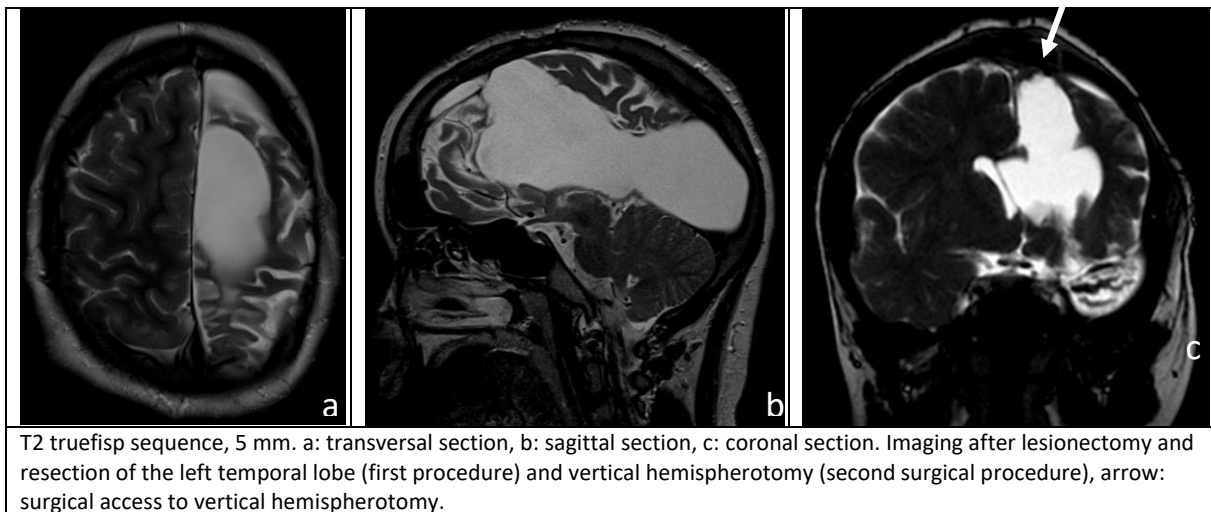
Postoperative MRI after second surgical procedure, Pat. 1, at age 13 years and two months.
